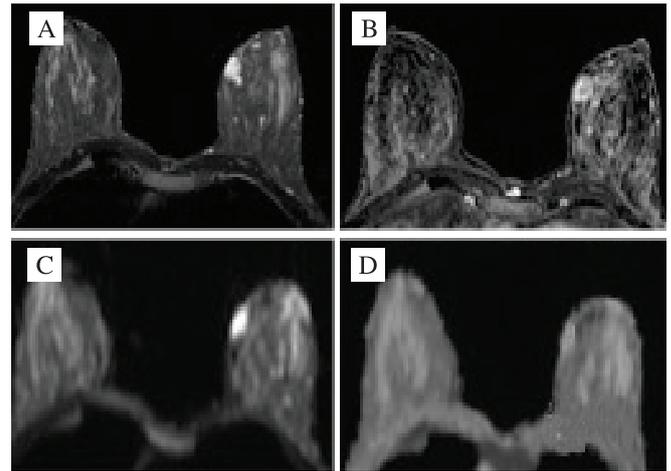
Axial MR images of the breasts of a 35-year-old woman with fibroadenoma of the left breast; A. Axial T2-weighted fat-suppressed MR image showing a well-marginated, lobular shaped hyperintense mass of the left breast; B. subtracted image showing mild enhancement of the mass; C. mass of the left breast showing high signal intensity on DWI; D. ADC maps showing obviously high signal intensity within the mass (The ADC value of the mass was $2.05 \times 10^{-3} \text{ mm}^2/\text{s}$.)
